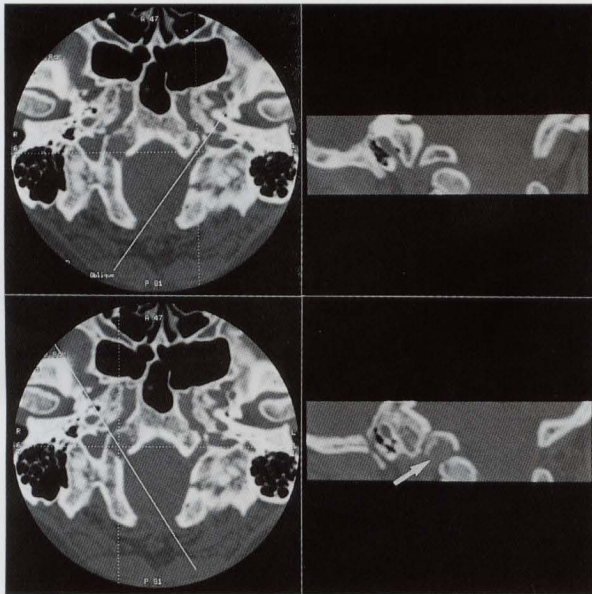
Oblique-sagittal multiplanar reconstruction CT image of both hypoglossal canals and nerves. Although the left canal is normal (upper two panels), the right canal is dilated in association with nerve enlargement (lower panels, arrow). The posterior skull-base metastasis lies along the course of the nerve.
